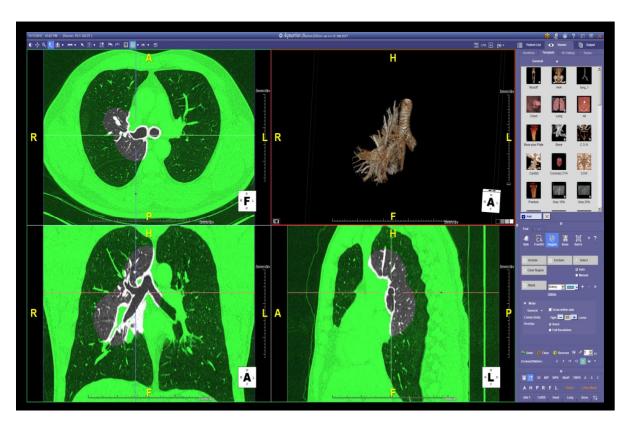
VBN by CT workstation (Aquaris iNtuition, TeraRecon).
